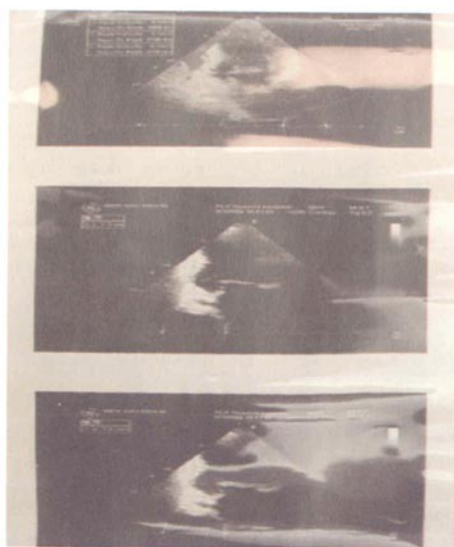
Echocardiography examination
